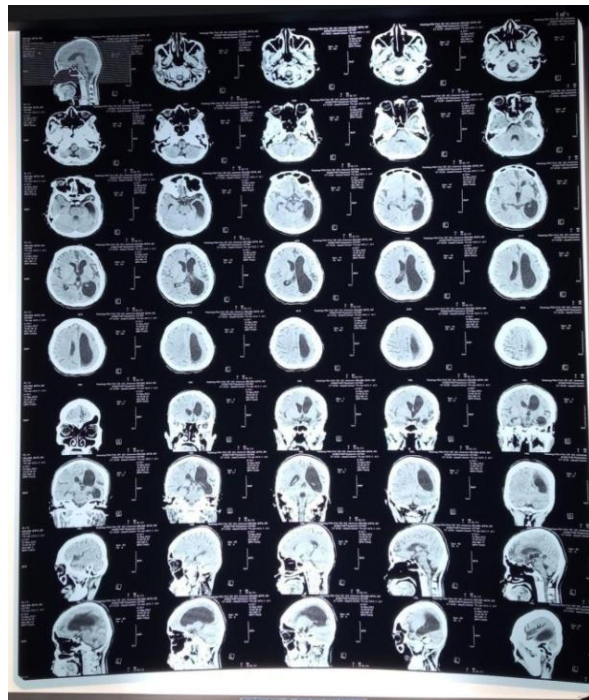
Head CT Scan Without Contrast
